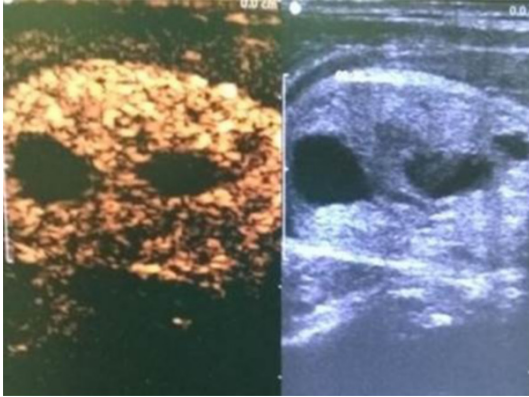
Contrast-enhanced ultrasonographic changes of the thyroid nodule before treatment.
